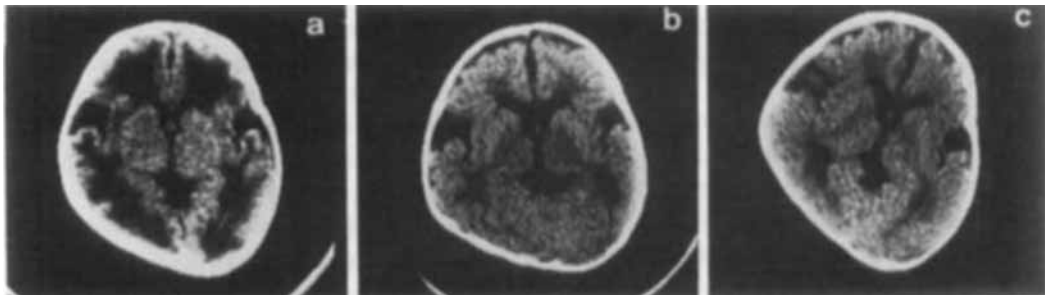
Brain CT of Case 3 at (a) 3 months (corrected age 0 month), (b) 9 months (6 months) and (c) 12 months (9 months) of age.
